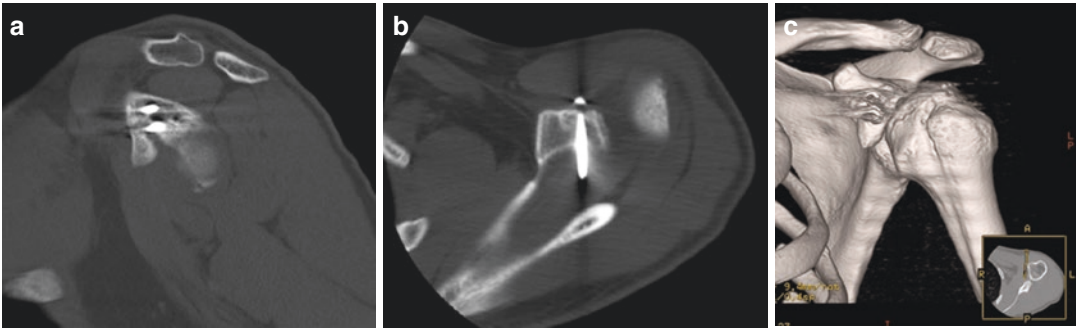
(a–c) Preoperative CT scan: bone graft and hardware malpositioning
